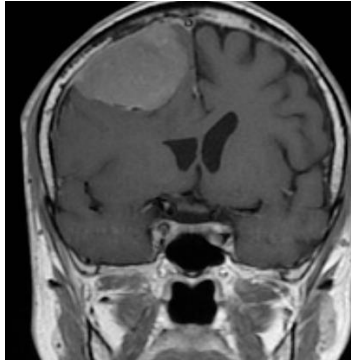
MRI brain, coronal cut showing right convexity meningioma
